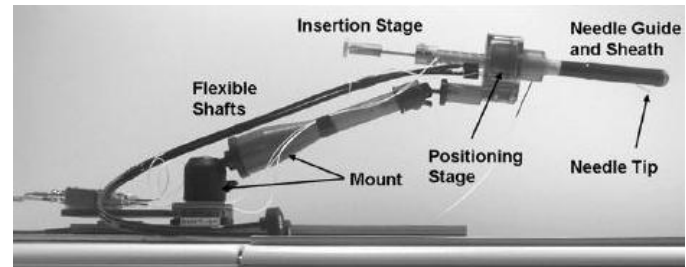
Side view of the MRI-compatible intra-prostatic needle placement device developed by Krieger *et al.* [2]
